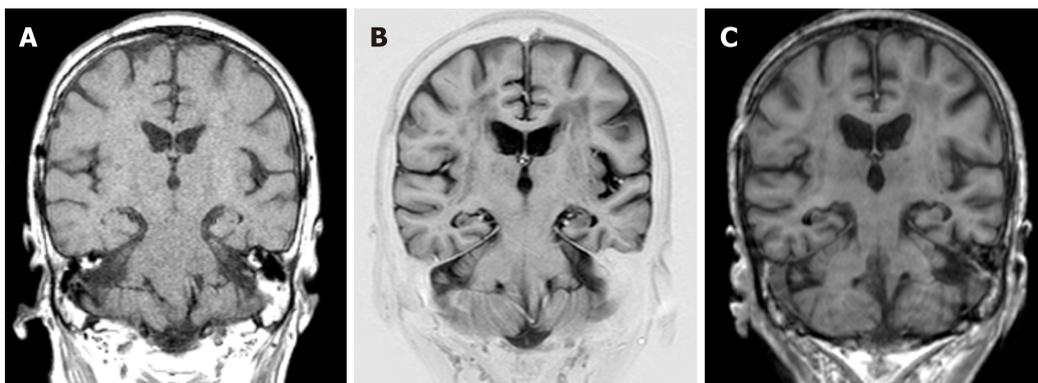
Magnetic resonance imaging-coronal images of the proband. A: 65 yr; B: 69 yr; C: 75 yr.
